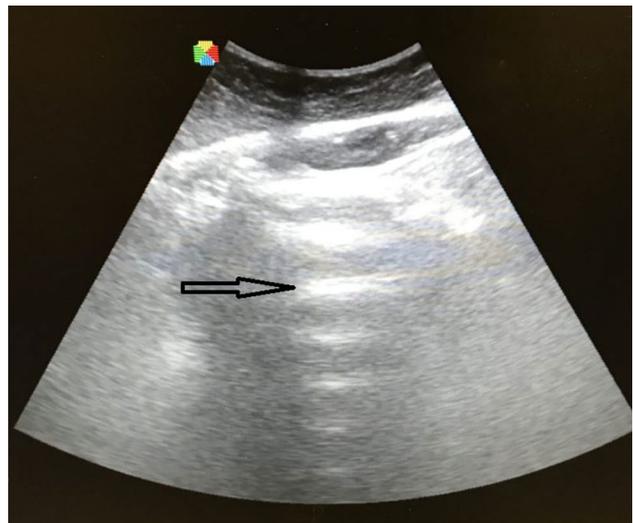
Bed-side ultrasonography of the perihepatic space with the patient in a supine position showing free intraperitoneal air as an echogenic line with posterior reverberations
